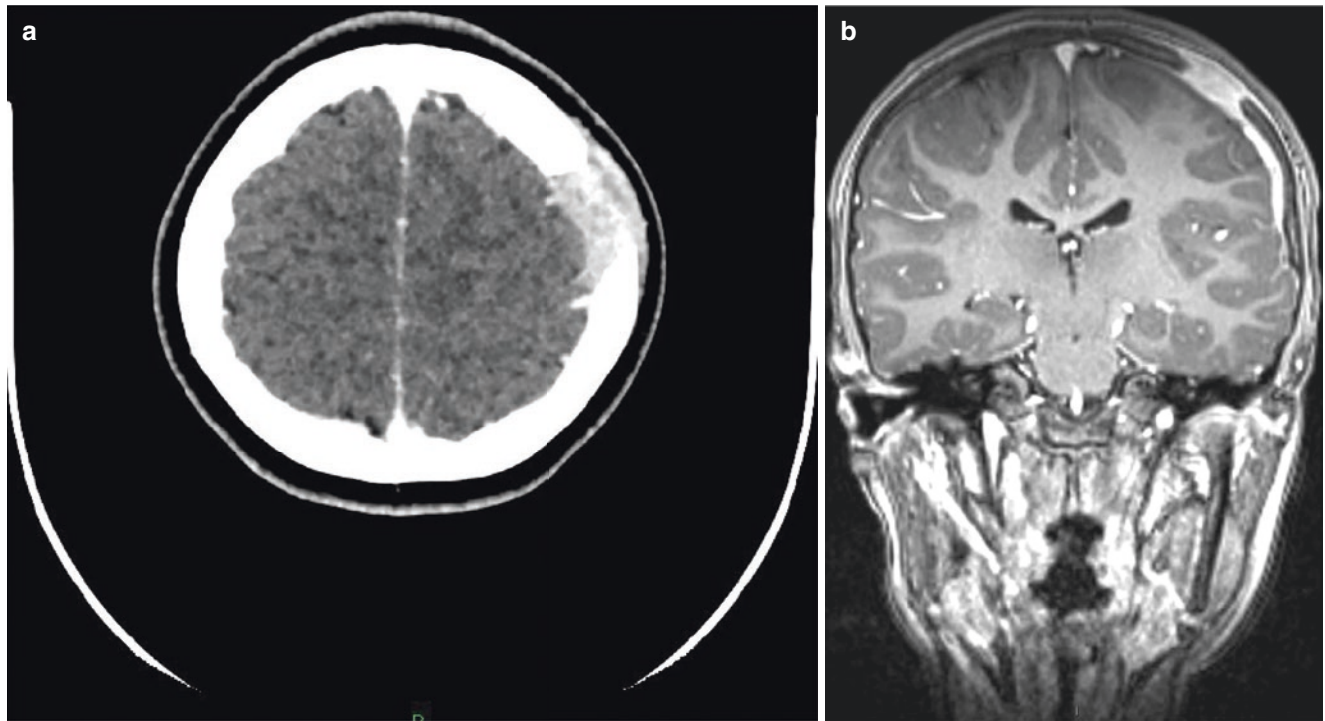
(a) Axial contrast-enhanced CT image shows thickening and enhancement of the dura subjacent to an LCH bone lesion. (b) Coronal post-contrast T1-weighted MR image demonstrates the extent of the dural thickening and enhancement in association with the LCH lesion
